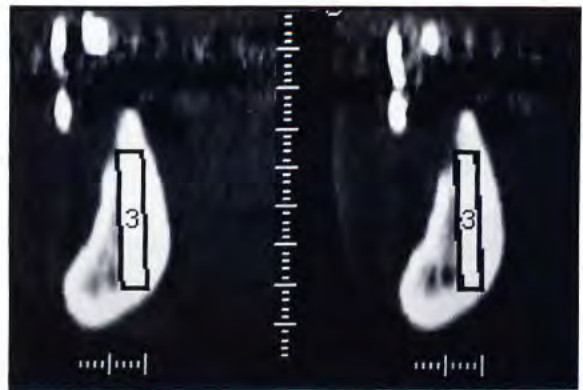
ACT scan taken with a CT appliance demonstrates a potential implant position (SIMPLANT).
